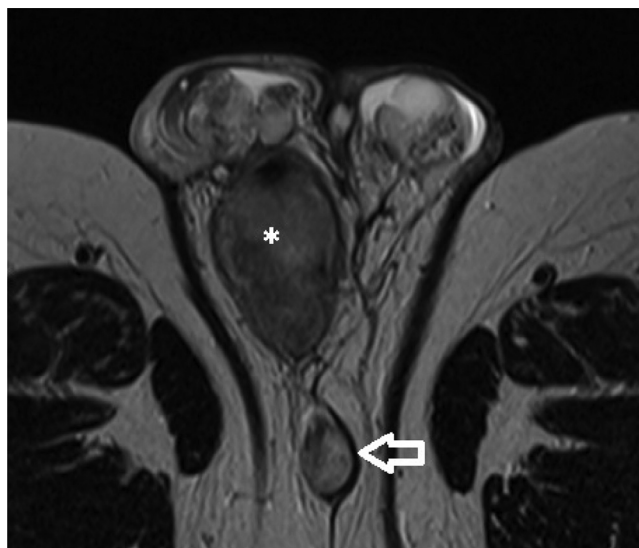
Axial T2-weighted TSE imaging three months following penectomy with perineal urostomy (arrow) demonstrates a new perineal mass (*) posterior to the scrotum proven to represent local tumor recurrence.
